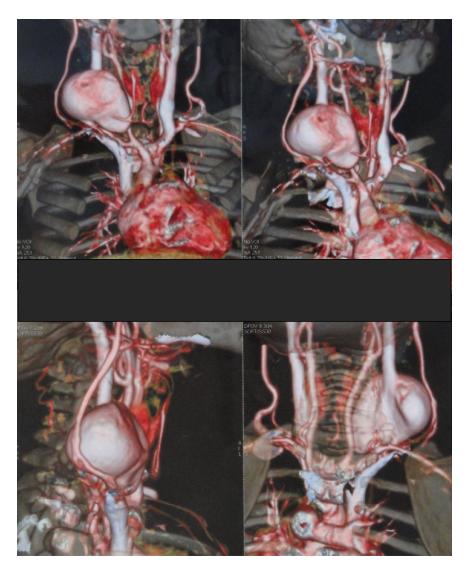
Contrast enhanced computed tomography (CECT) of the neck and the chest with 3-dimensional reconstruction, shows a $25.5 \times 34.3 \times 26.6$ mm (anteroposterior \times transverse \times craniocaudal) fusiform dilatation of the right internal jugular vein ending approximately 5 mm above its junction with the right subclavian vein.
